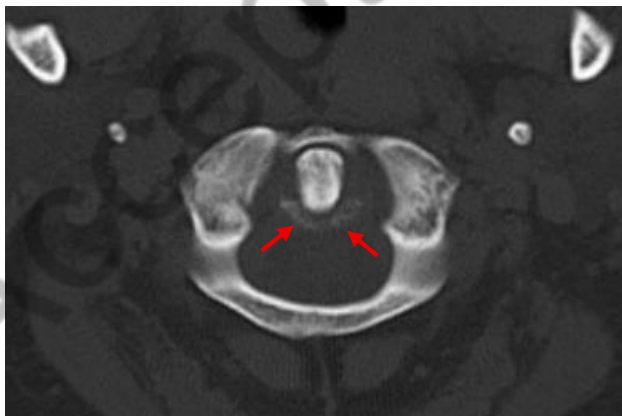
Case 1 (asymptomatic) - Transverse cervical CT scan showing linear calcifications of the atlas transverse ligament (arrows).
